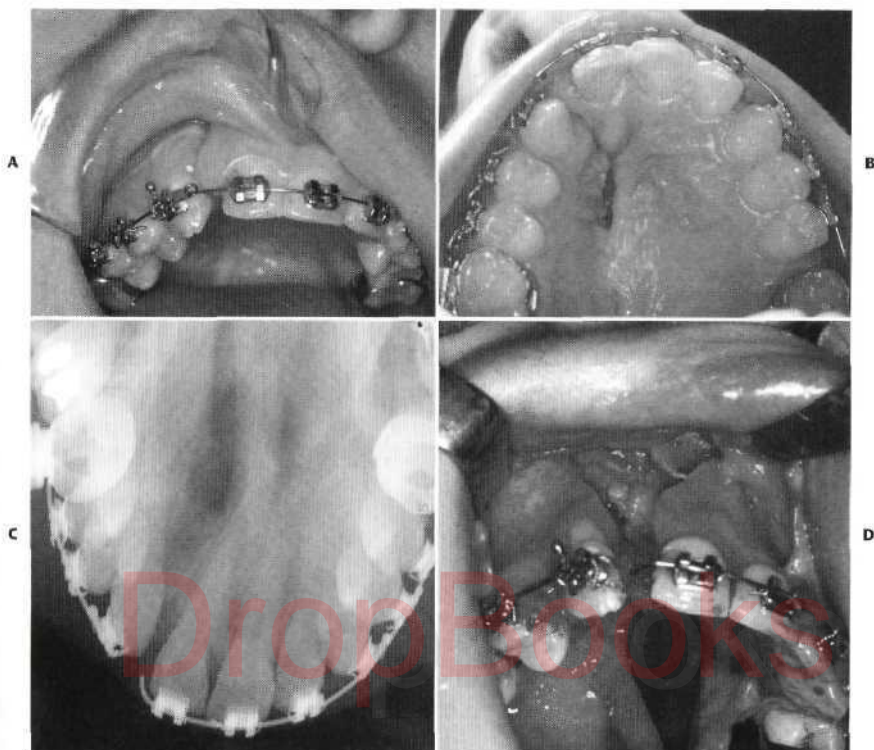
Labial (A), palatal, (B) and radiographic (C) views of a patent unilateral alveolar cleft that extends posteriorly along the hard palate. D, Photograph shows surgical closure of the nasal mucosa with inversion into the nasal cavity.
